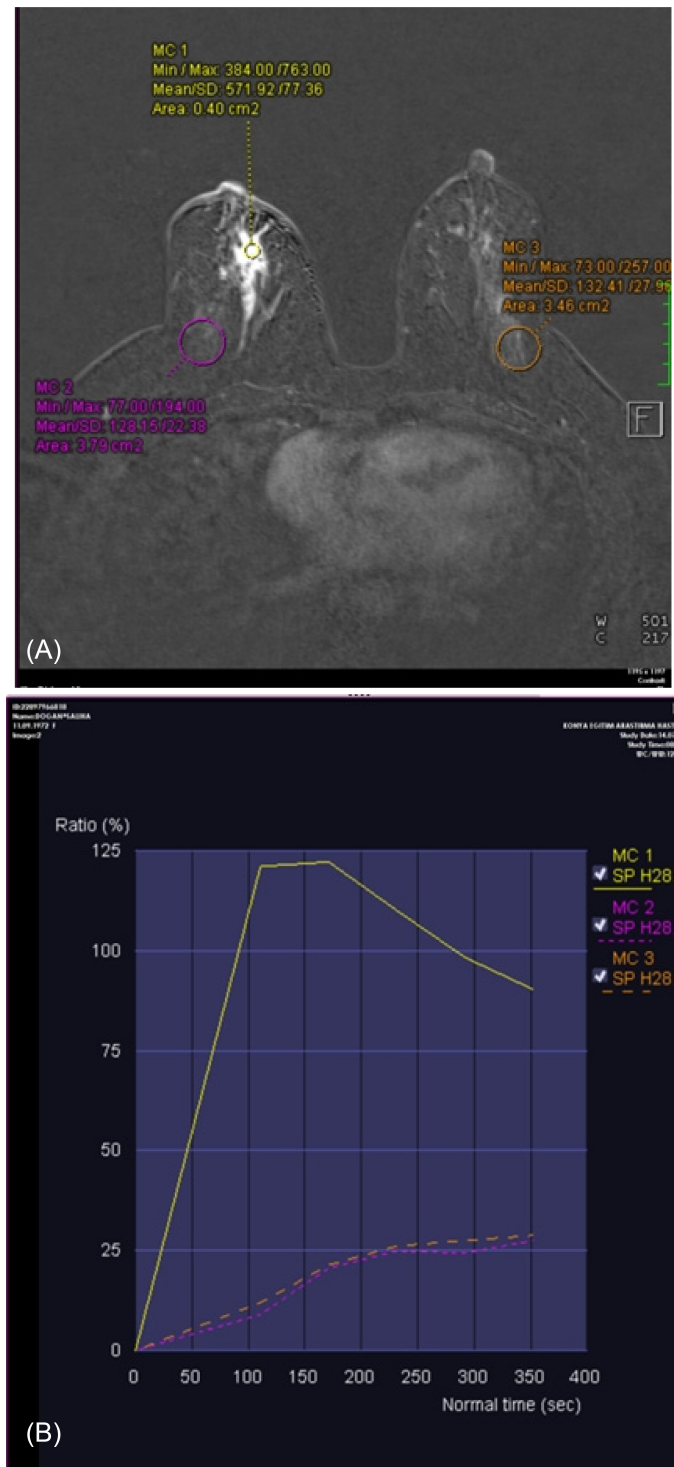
On breast MRI, a 45-year-old female, a mass measuring 15 × 15 mm with linear shape and partly spiculated margins was located in the right breast retroareolar region and was diagnosed as invasive ductal carcinoma according to the biopsy results. (A) The mean curve measurement of mass enhancement, non-mass enhancement, and parenchymal enhancement in the contralateral breast on DCE Breast MRI using ROI. (B) Time–intensity curve displays type 3 mass enhancement pattern, non-mass enhancement, and parenchymal enhancement in the contralateral breast display type 1 pattern.
